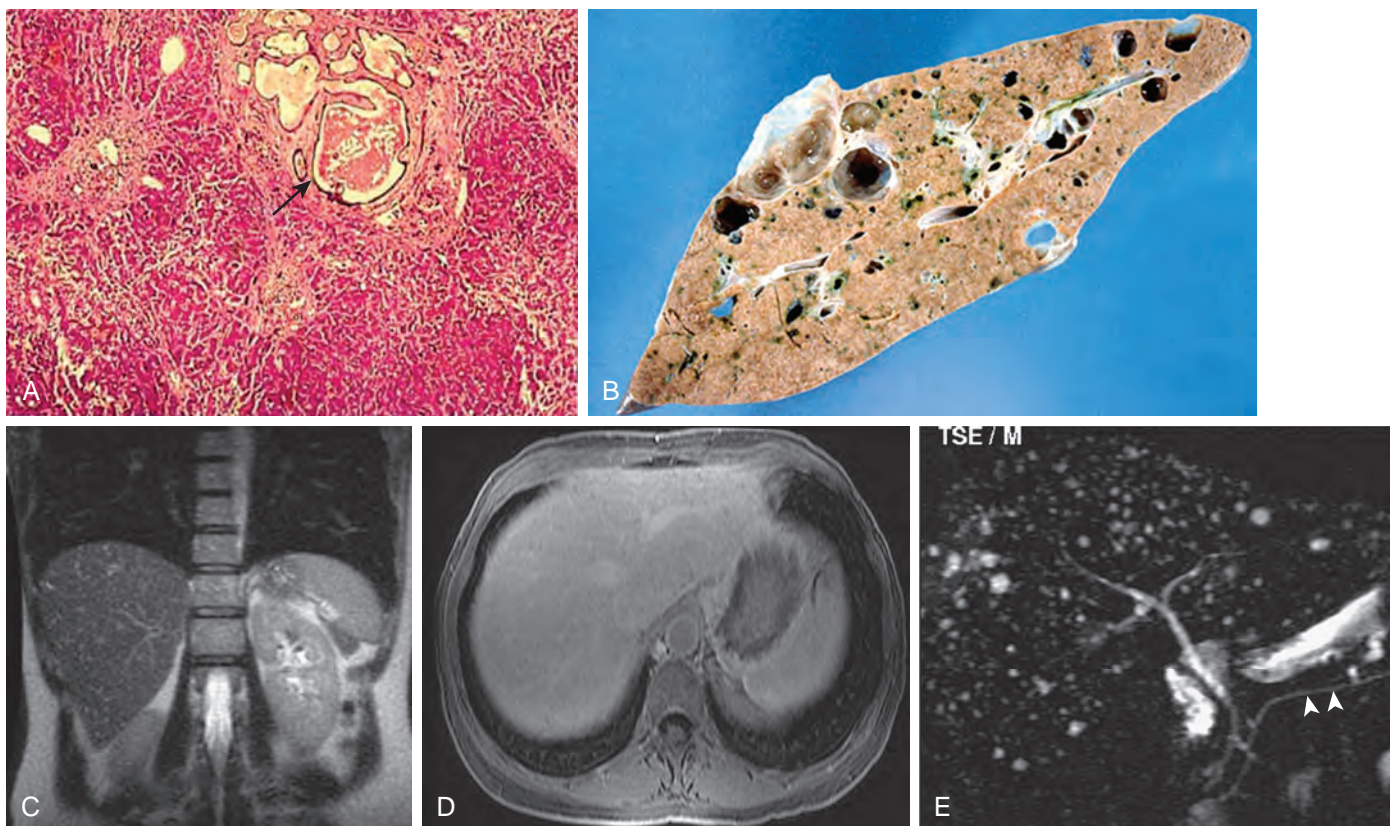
Multiple bile duct hamartomas (von Meyenberg complexes). A. These are small bile ductules embedded in a fibrous, sometimes hyalinized stroma. Each lumen may contain inspissated bile concretions (arrow), and the lumina may interconnect. These are usually incidental findings at autopsy and cross-sectional imaging. B. They are usually small and multiple, located in the subcapsular region and distributed in both lobes. C. Coronal, T2-weighted MRI scan shows multiple, tiny hyperintense lesions in the liver. D. MRCP images show these hyperintense lesions. They have fluid (bile) signal intensity. E. MRCP image demonstrates innumerable tiny hyperintense cysts typical of this disorder. Arrowheads point to pancreatic duct.
